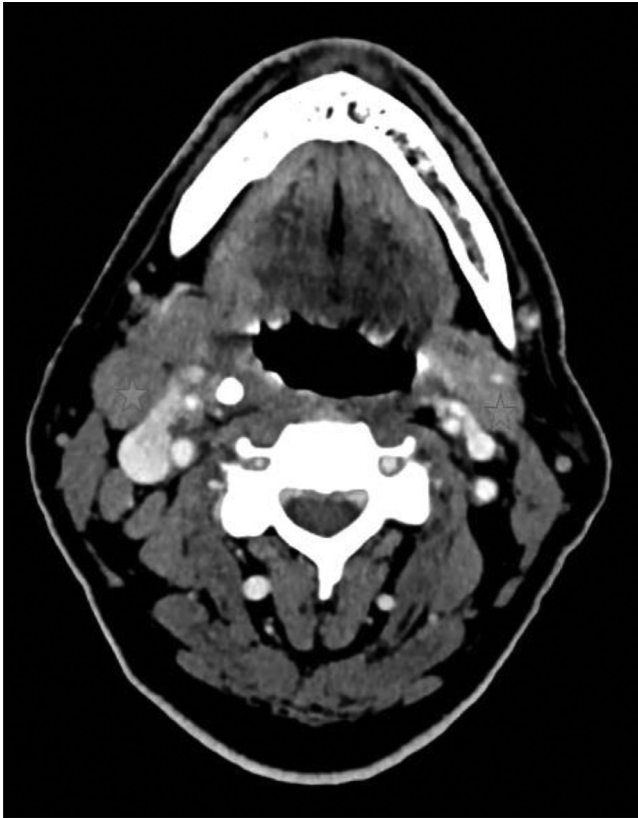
Axial neck CT scan with IV contrast approximately 17 days following reported symptom onset. Demonstrates bilateral upper jugulodigastric lymphadenopathy (blue stars).
